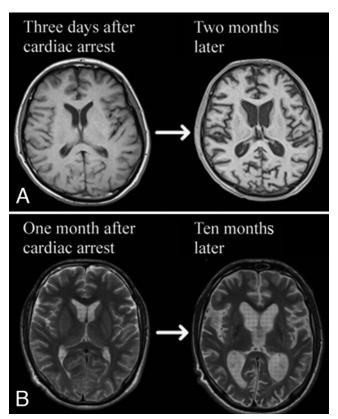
MR images obtained in 2 patients with a similar MRI appearance. The upper pair of images (A) are from a patient in MCS (Case 1), who satisfied the entry criteria for the study and underwent DBS electrode implantation, resulting in a complete recovery of consciousness. The lower pair of images (B) are from a patient who did not satisfy entry criteria for the study. Note the brain atrophy with enlarged ventricles and pronounced sulci after 2 months (A, *right*) and 10 months (B, *right*) in coma compared with the MR images obtained 3 days and 1 month after cardiac arrest (*left* images in A and B).
